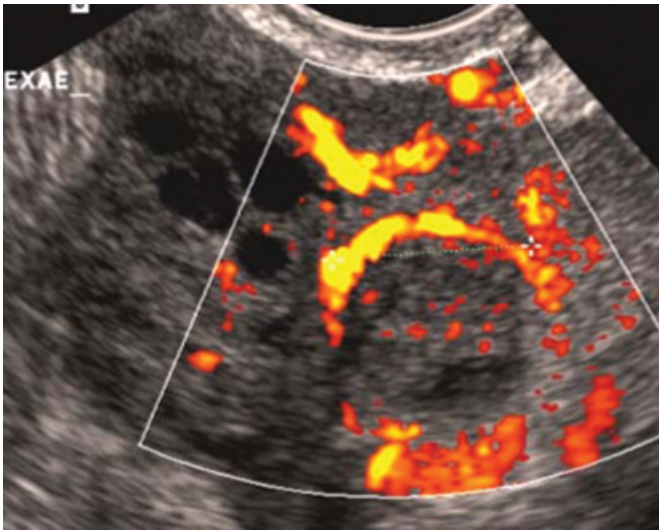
Corpus luteum shows the vascular ring with colour Doppler.
